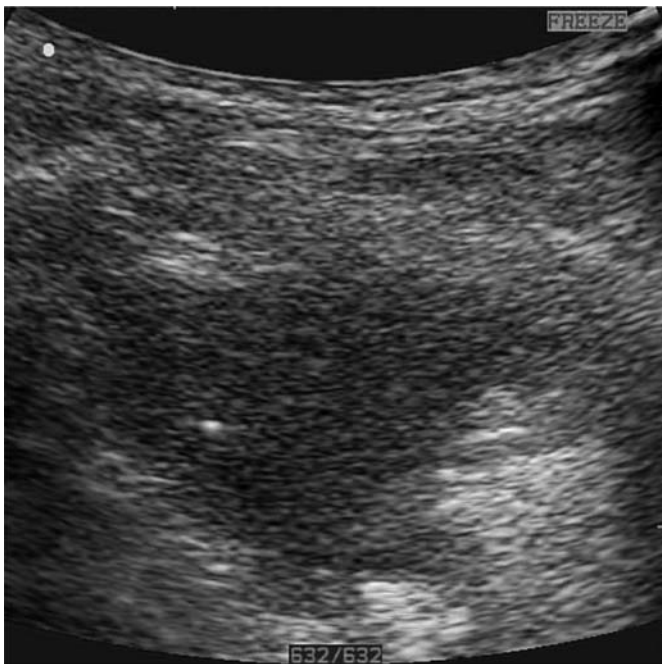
Empyema: sonogram. As a complication of pneumonia, parapneumonic empyema developed in a 27-year-old patient with drug addiction. Pleural empyema is characterized by an echo-rich effusion, multiple echogenic structures within the effusion (resembles a net or Swiss cheese) and an absorbed lung.
